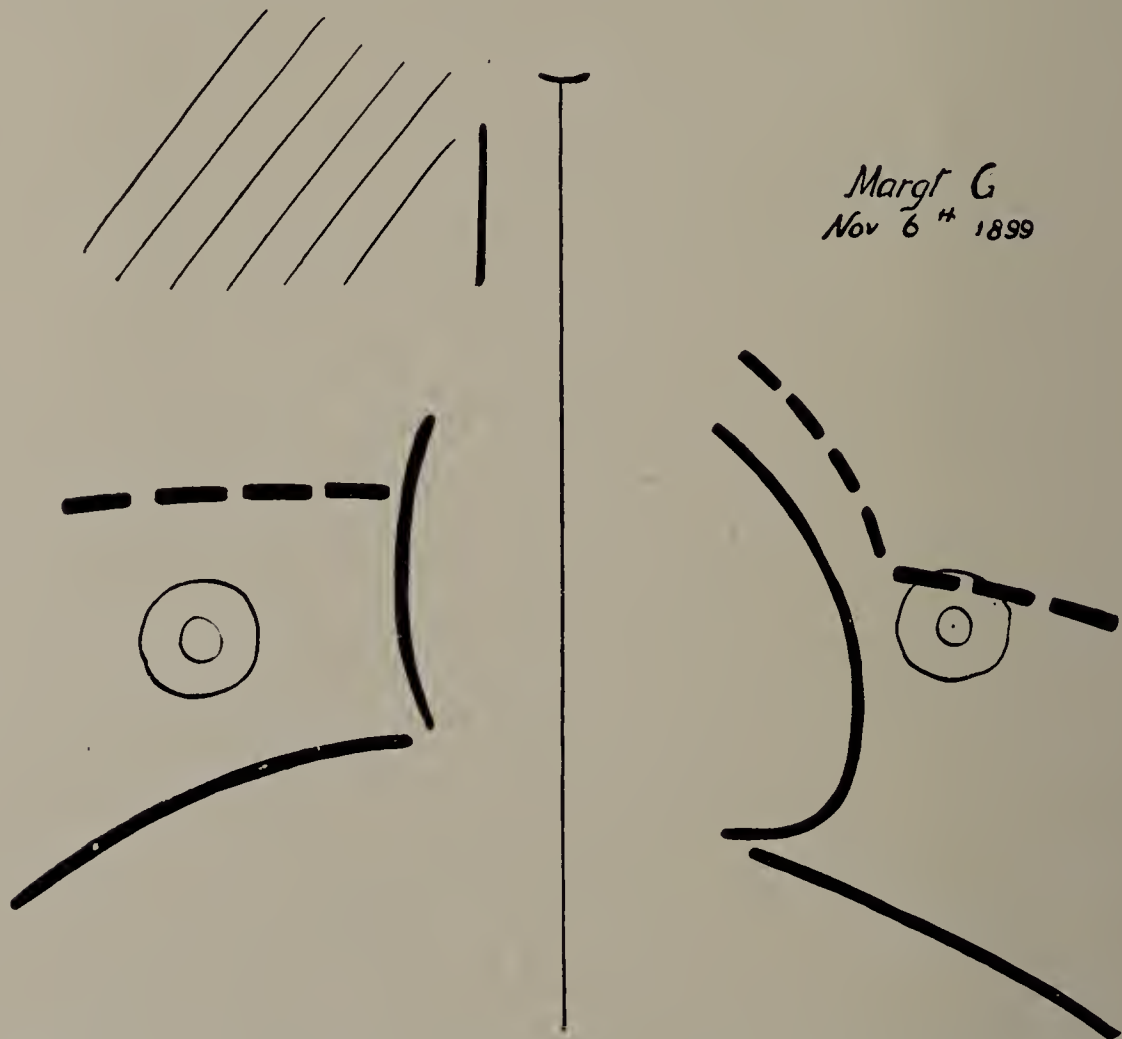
Margaret G. X-ray tracing made November 6, 1899. (One-third life size.) Right apex still darker than normal, and excursion of diaphragm shortened on right side.
